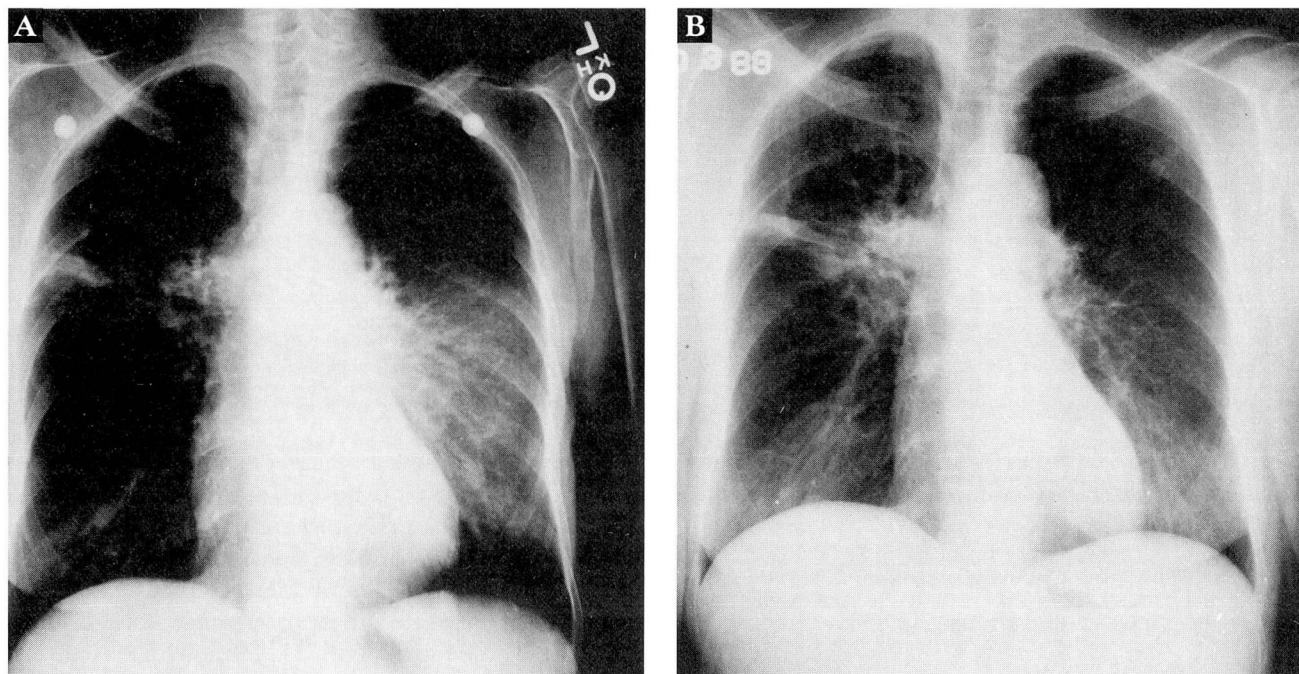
(A) Posteroanterior chest x-ray upon admission revealing an extrapleural soft tissue density on the left, right hilar fullness, and perihilar infiltrate. (B) Repeat posteroanterior chest x-ray following aspiration of 330 cc of purulent material from the left breast/chest wall.
